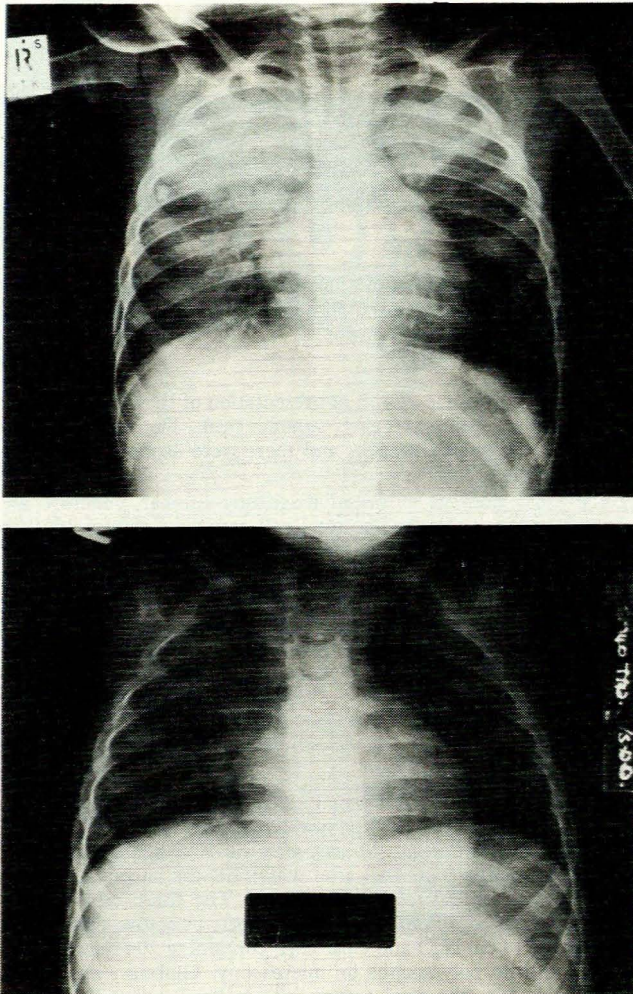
Case 1: chest radiograph (top) on admission showing bilateral pulmonary opacities with air bronchogram visible in the right upper zone; and (bottom) 2 days later showing resolution.
